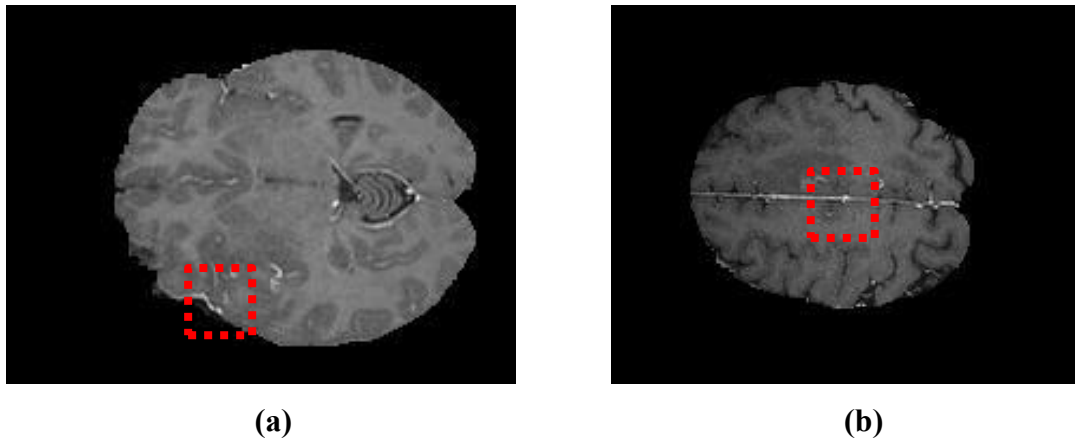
Abnormal MRI slices in the presence of tumour inside the red square in terms of intensity homogeneity from challenge MICCAI (BRATS 2012-BRATS-1) dataset, (a) Slice 85 of patient BRATS_HG0004, and (b) Slice 127 of patient BRATS_HG0007
